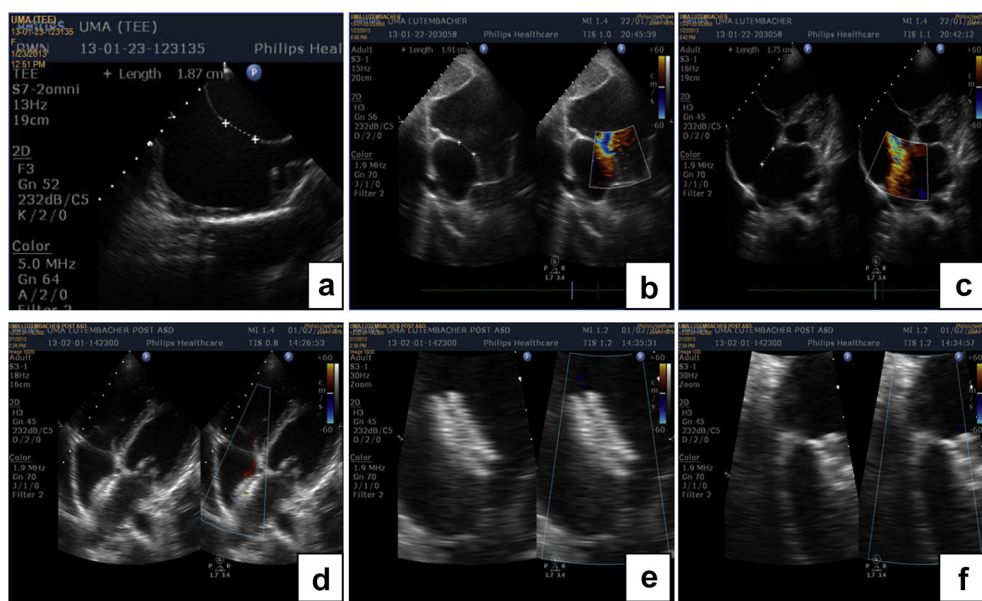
(a, b and c) OS-ASD in bicaval view on TEE, modified subcostal bicaval view and apical 4 chamber view on TTE. (d) The ASD device in apical 4 chamber view and (e and f) Subcostal views showing device holding SVC and IVC rims tightly respectively.
